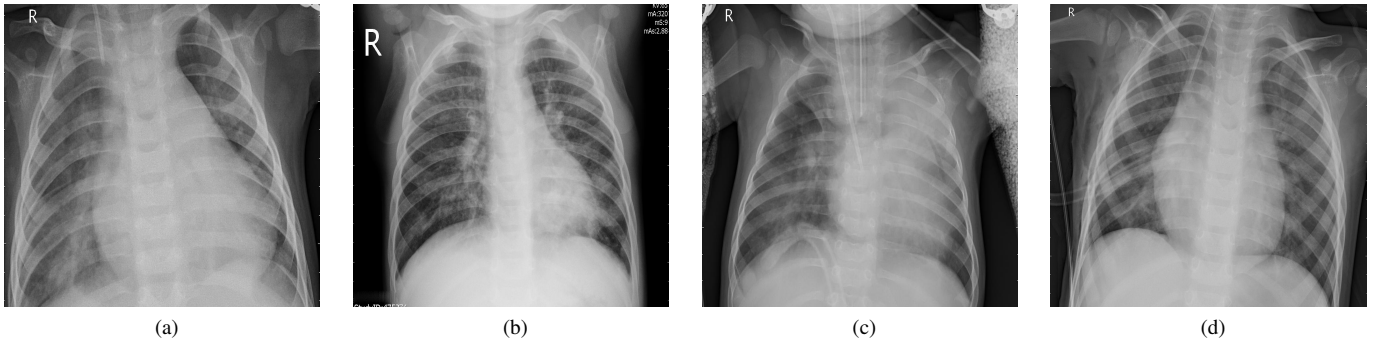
Pneumonia affected Chest X-ray Images. Lung, Heart and diaphragm are not clearly visible.
